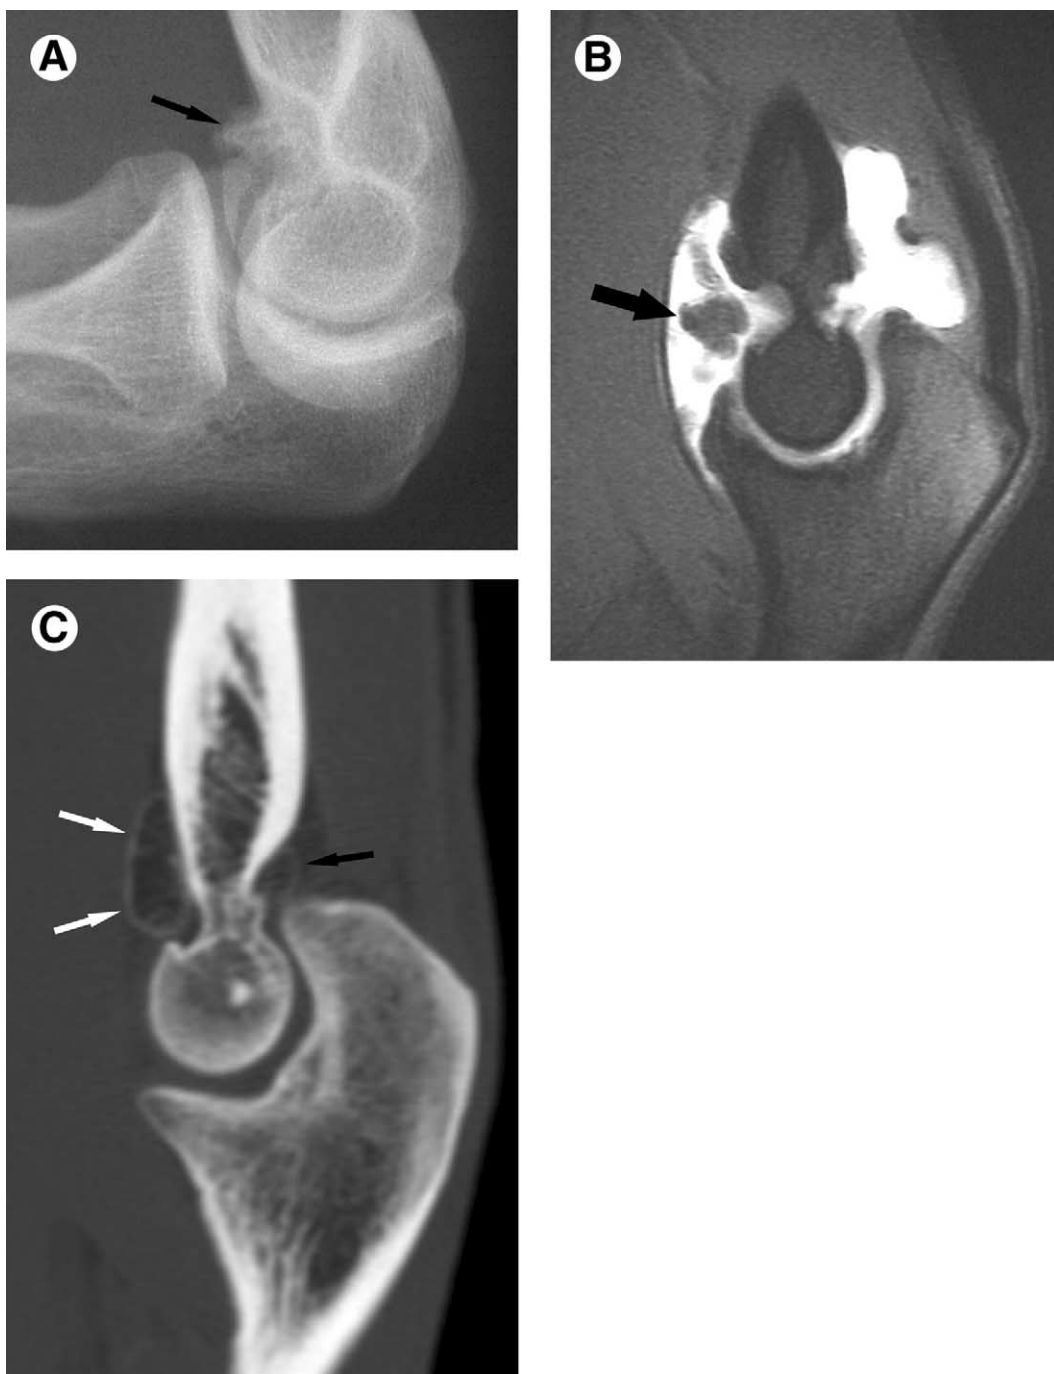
Loose bodies. (A) Lateral radiograph reveals calcified body in region of the coronoid recess (arrow). (B) Sagittal T1-weighted MR arthrogram image with fat saturation confirms presence and location of intraarticular body (arrow). This technique enjoys high sensitivity in detection of loose bodies and is helpful in distinguishing true loose bodies from those sequestered within synovium or adjacent bursa. (C) Sagittal reformatted CT image in different patient demonstrates ossified bodies within anterior (white arrows) and posterior (black arrow) joint recesses. Posterior loose body was occult radiographically.
